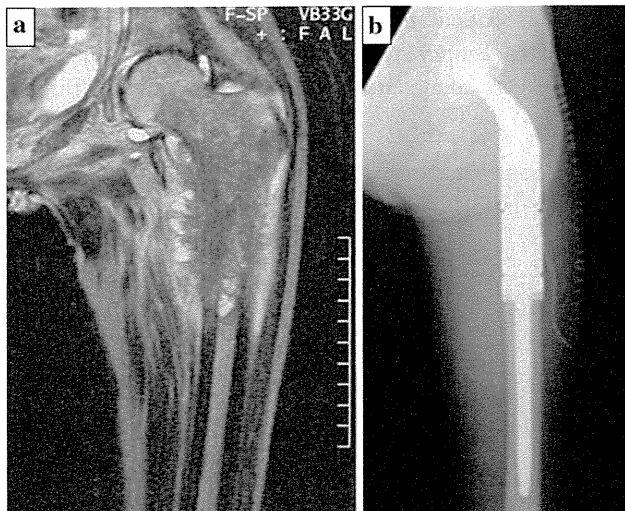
Case 3. a Coronal T2 view of MRI shows the bone metastases of proximal femur. b Plain film shows the endoprosthetic replacement after tumor resection
